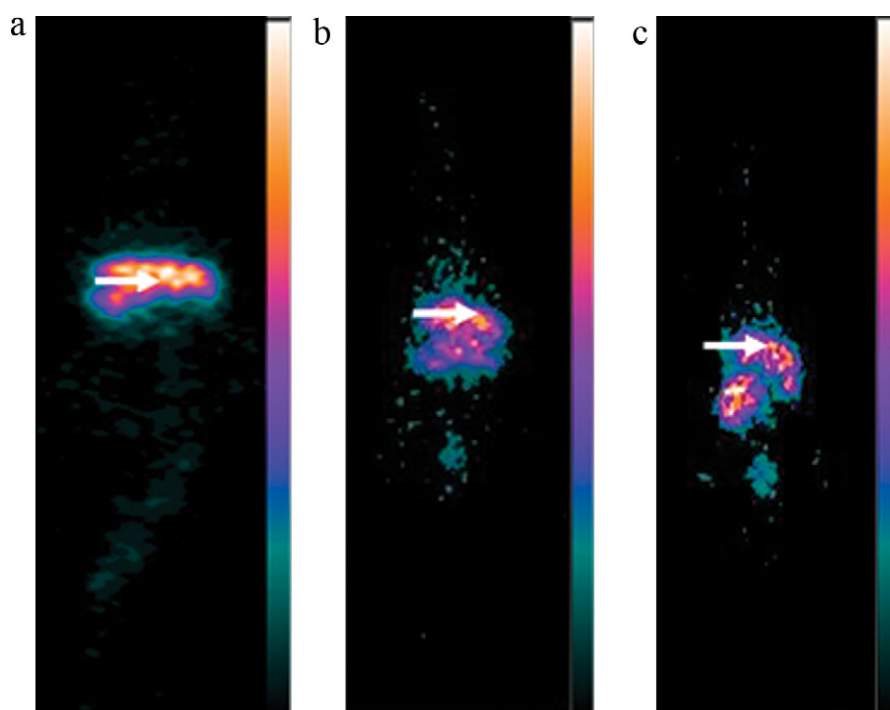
Gamma scintigraphic images depicting biodistribution profile post 5 h administration of (a) DOX solution (b) PES-DOX NP (c) PES-DOX-PUL (\rightarrow = liver marker).
